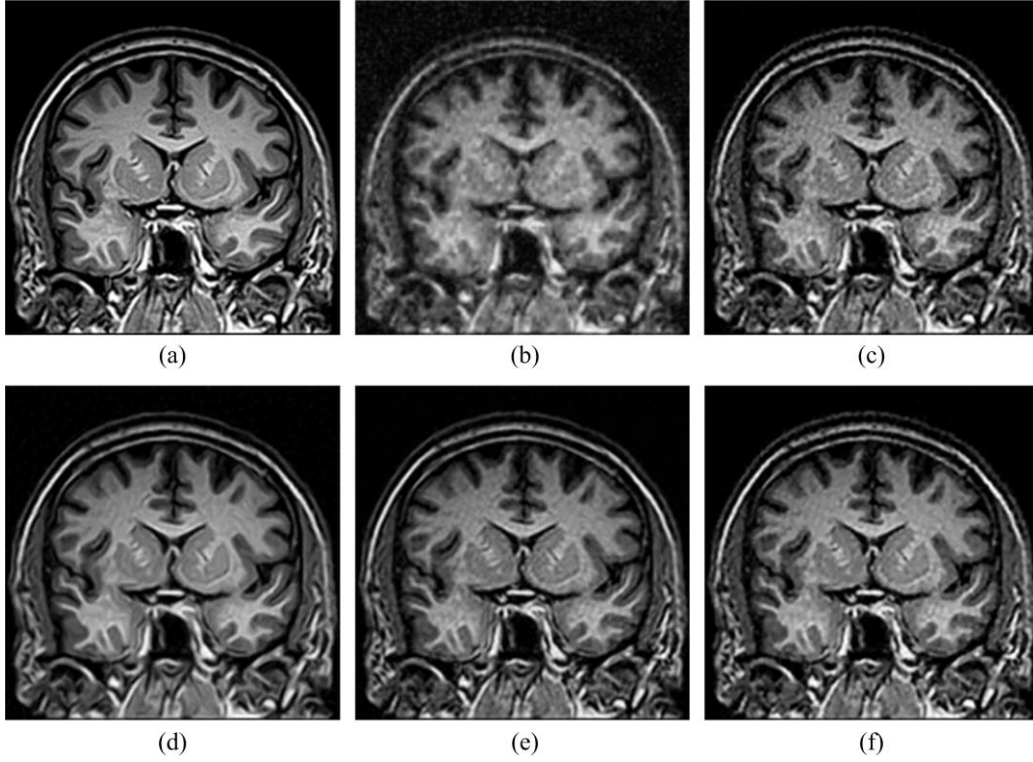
Results of reconstruction on the coronal brain MR image using different methods with 15% sampling. (a) Original MR images, images reconstructed by, (b) SparseMRI, (c) FCSA, (d) Framelet+NLTV, (e) Shearlet+TGV, (f) Data-driven TF+TGV (proposed).
